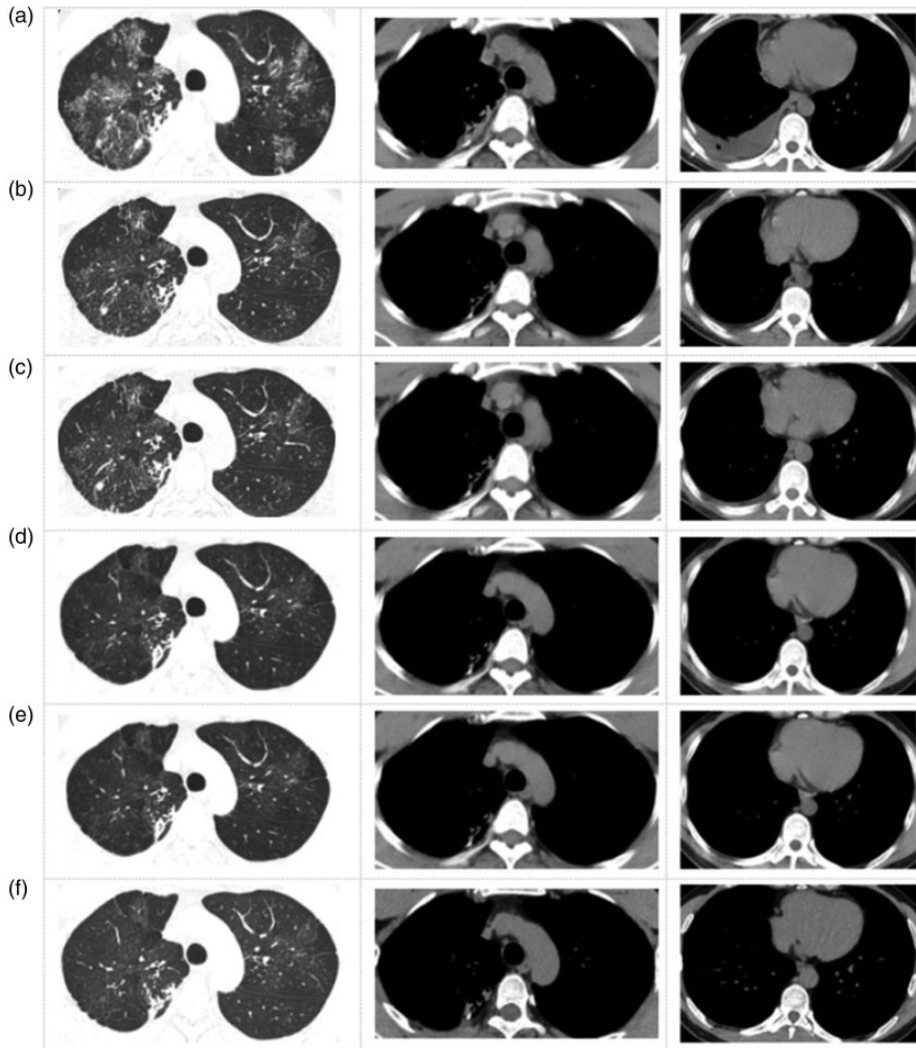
Chest computed tomography (CT) images: (a) images taken in January 2016 during the patient's second hospitalization at 1 week after contracting an upper respiratory tract infection. The images show the following: multiple patches and small nodular densities in both lungs; the edge was blurred; the right pleura was thickened; nodular calcification was seen; a small amount of effusion was seen in the right pleural cavity; punctate gas shadow was seen in the right pleural cavity; there were multiple small lymph nodes in the mediastinum, which indicated pulmonary infectious lesions and a high possibility of tuberculosis infection and (b–f) images showing that the lung lesions and thickened pleura gradually improved and the pleural effusion was completely absorbed (b: February 2016; c: May 2016; d: September 2016; e: May 2018; f: December 2019).
